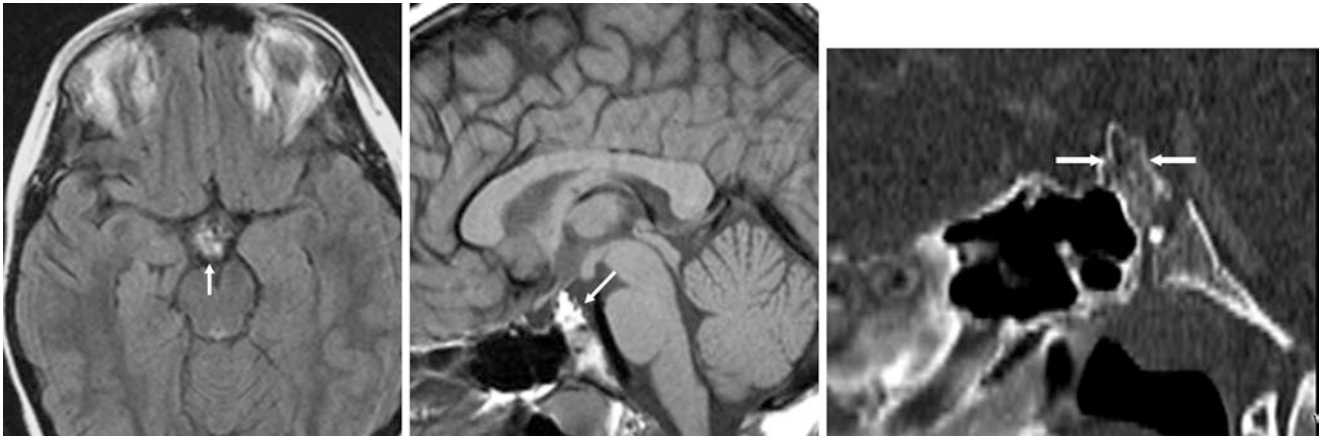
A 12 year old with a bright focus on non-fat suppressed sagittal T1WI (*left*) and FLAIR (*middle*) MR images. This was thought to be a mass dorsal to the pituitary but was later found to be a prominent dorsum sella on sagittal NECT reconstructions (*right*) that contained fatty marrow
